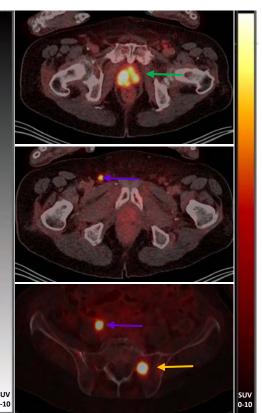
[68Ga]Ga-PSMA-11 PET/CT Scan
